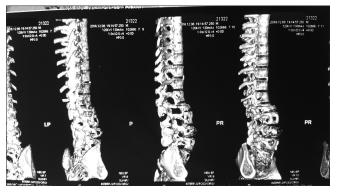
Computed tomography lumbosacral spine with three-dimensional reconstruction
